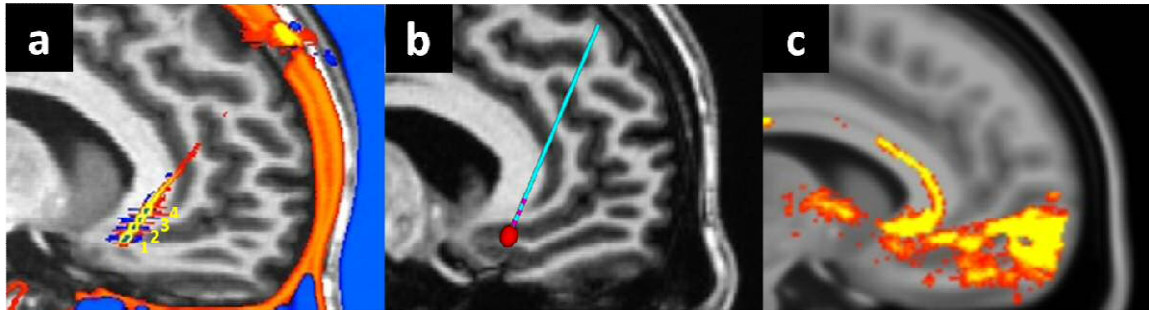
Identification of contact location, a: post-surgical CT image overlapped onto pre-surgical T1 image for one subject. Contacts are numbered inferior to superior, 1 to 4. b: Activation volume using contact 1 and typical parameters for a sample subject (130Hz, 90us, 6mA), c: Probabilistic tractography connection from calculated activated volume for one subject.
